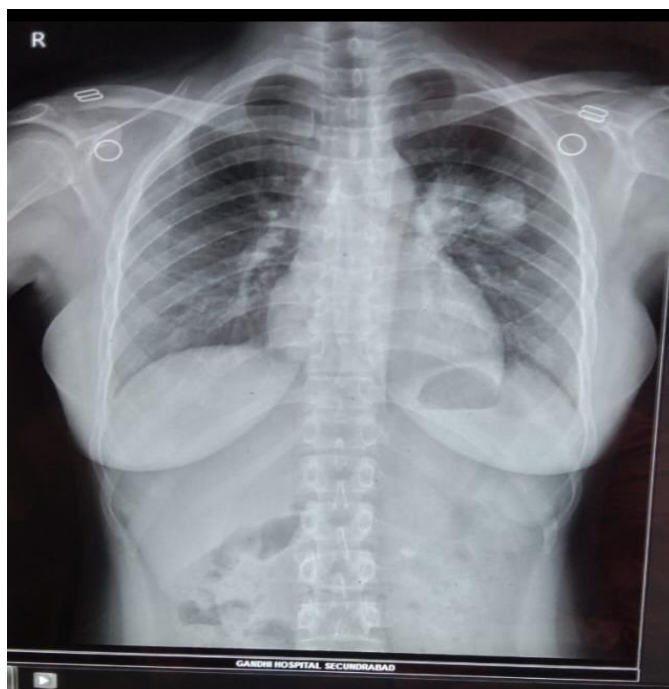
Chest radiograph (PA view), Gandhi Hospital, Secunderabad, October 2023, obtained during the workup for pleuritic chest pain, at the time bronchoscopy and BAL galactomannan confirmed invasive pulmonary aspergillosis. Patient identifiers have been redacted.
